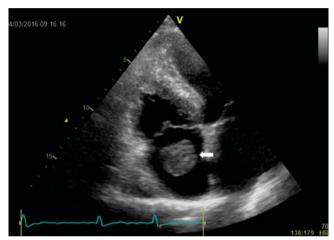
Transthoracic echocardiography, apical 4-chamber view focused on the right cavities showing big ball-like thrombus in the right atrium (arrow) with no attachment to the right atrial structures.
